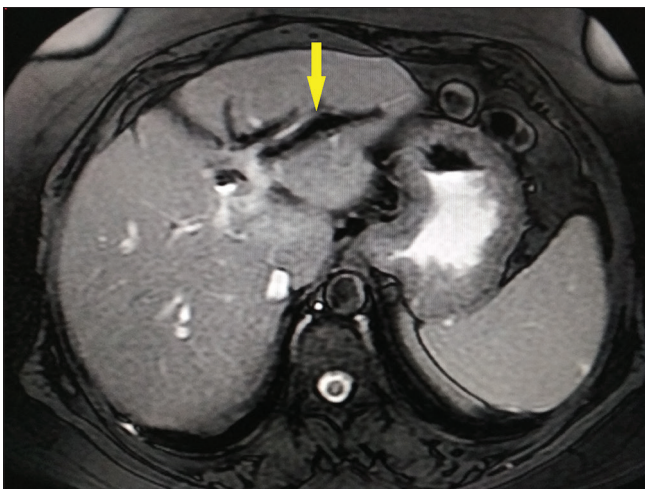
Axial 2D FIESTA MR image demonstrating pneumobilia (arrow) in a 40-year-old female patient who underwent side-to-side choledochoduodenostomy
